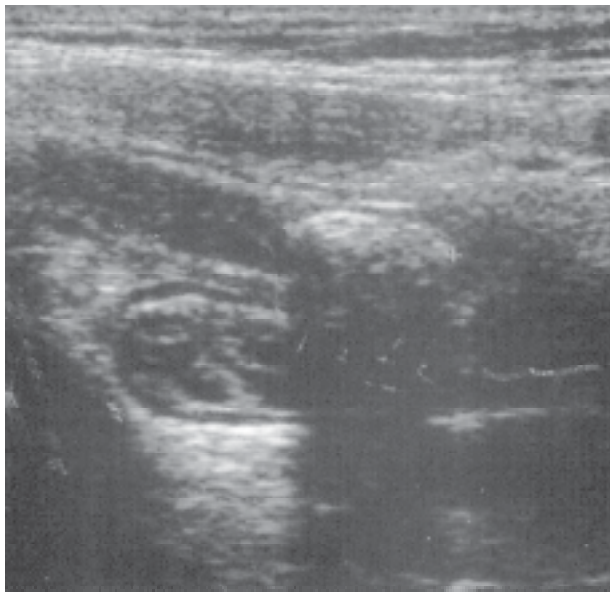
Acute appendicitis: longitudinal sonogram shows a dilated fluid-filled appendix with an echogenic appendicolith.
